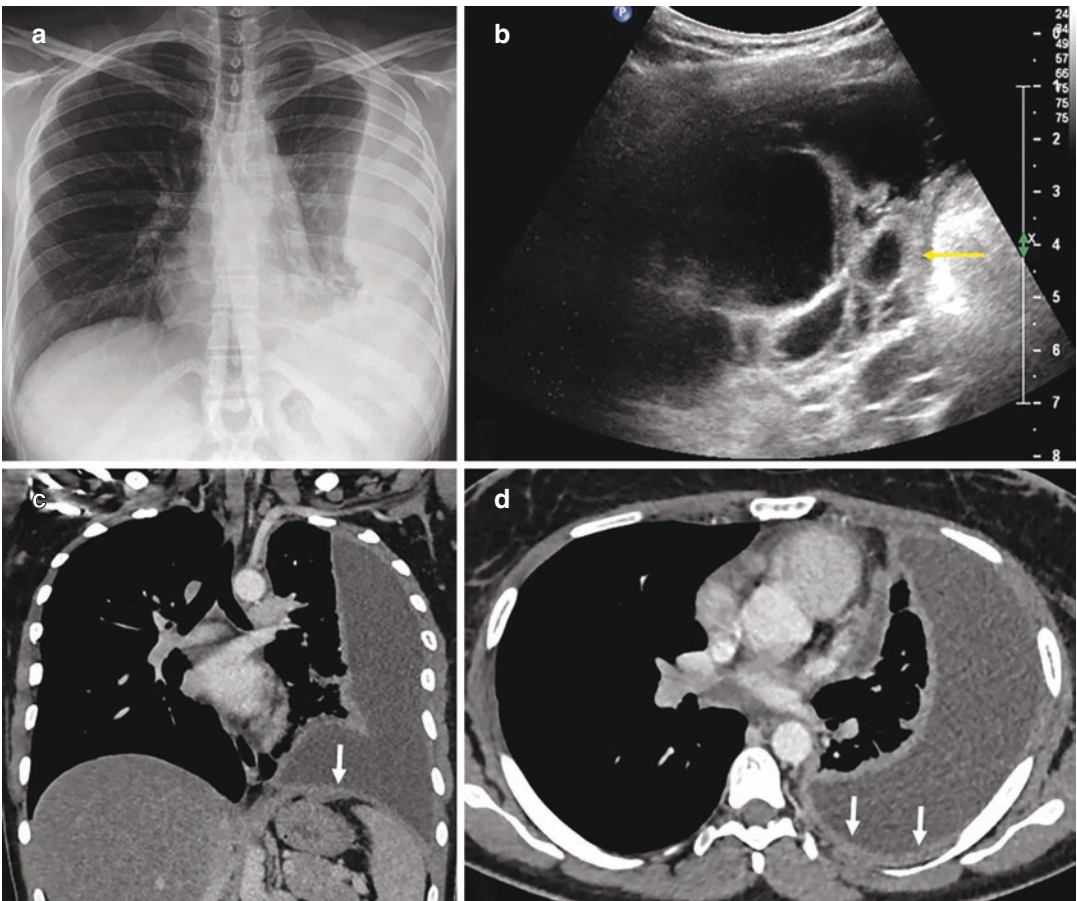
Pleural tuberculosis in a 29-year-old woman. (a) PA chest radiograph shows a large left pleural opacity. (b) Lateral thoracic US image shows an anechoic pleural effusion with septations and thickening of parietal pleura (yellow arrow). (c) Coronal and (d) axial contrast-enhanced CT images confirm left pleural effusion and thickening (white arrows)
